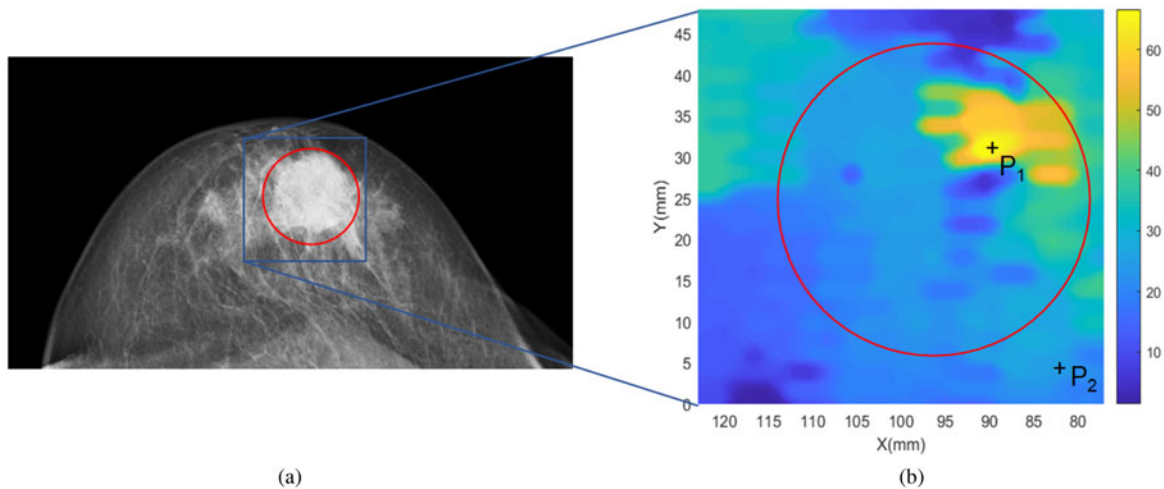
Comparison between X-ray image and microwave image for patient A. The microwave image is estimated through time delays caused by the propagation through the breast when compared to air. Locations with higher relative permittivity could be interpreted as cancerous tissue. The final thickness of the compressed breast is 44 mm during microwave examination and is 41 mm during X-ray examination.
